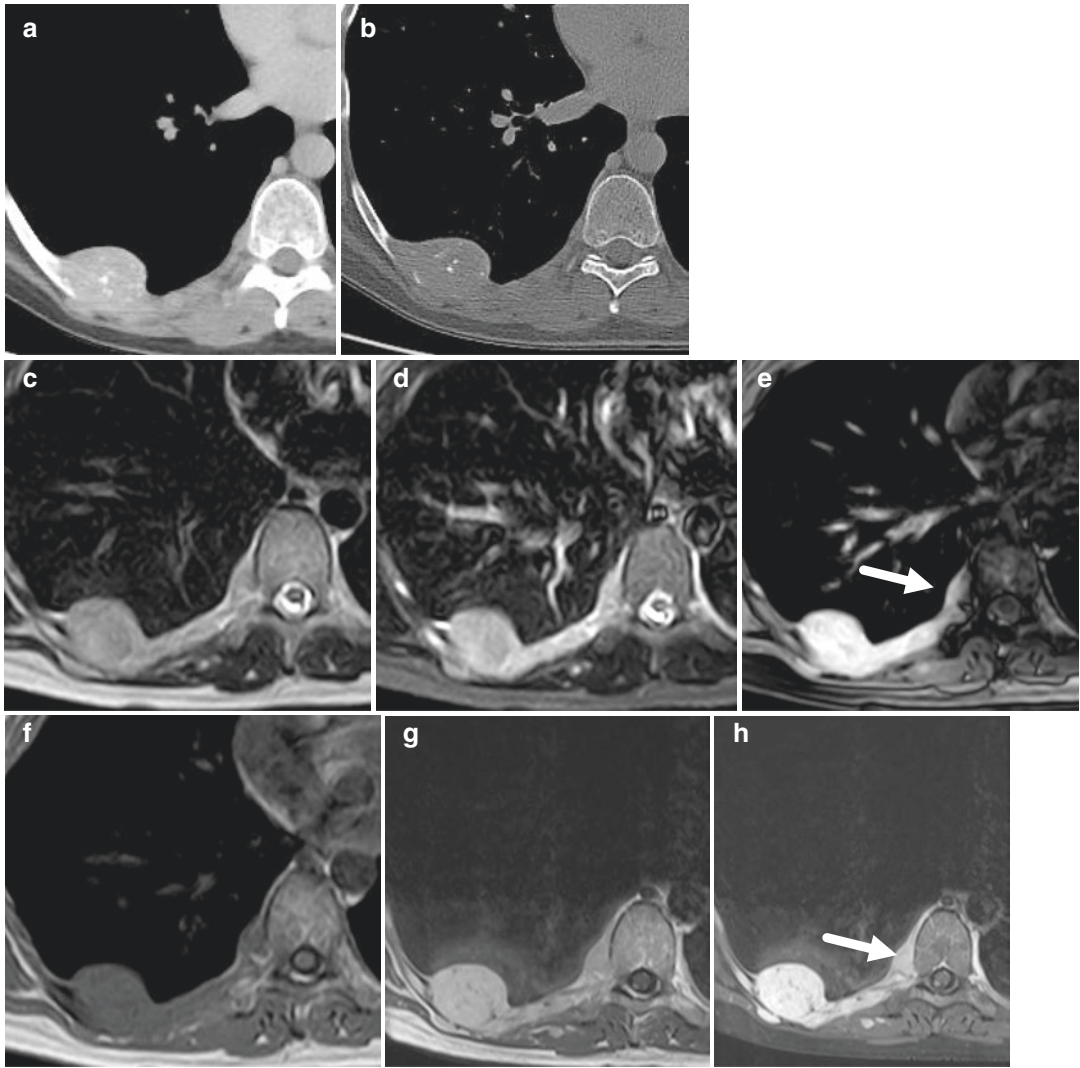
Nodular mass of 3 cm was detected at CT of a 33-year-old female with destruction of and along the rib and calcification dots (a, b). T2 signal was homogeneously high (c–e), especially after fat suppression (e). T1 signal was homogeneously intermediate (f) with significant uptake of contrast agent (g, h), especially after fat
